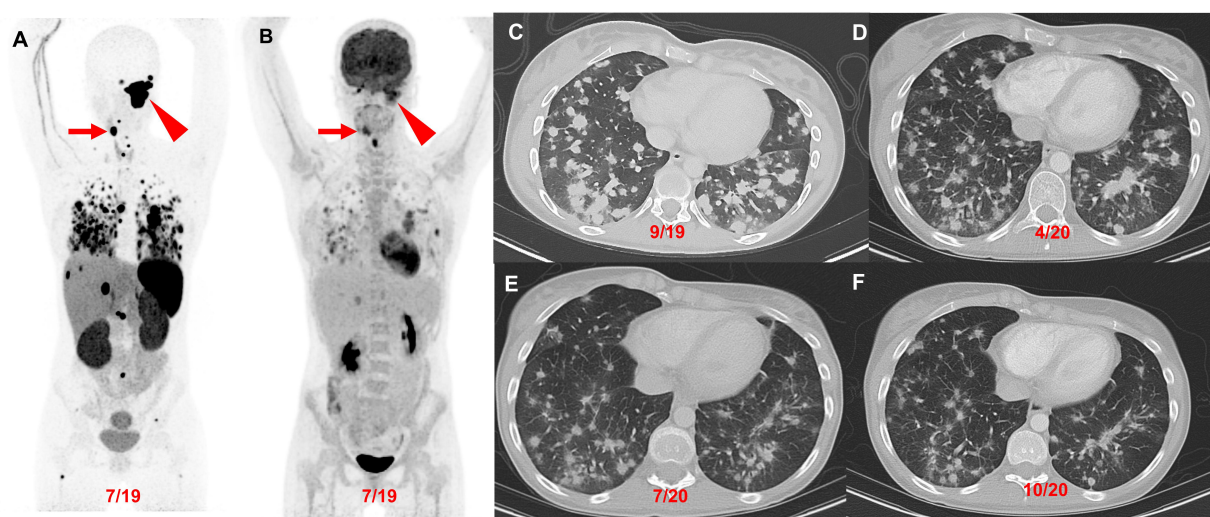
Patient 2 (23-year-old female, *SDHD* pathogenic variant), serial images throughout the course of treatment: Anterior maximum intensity projection images of ^{68}Ga -DOTATATE PET/CT (A) and ^{18}F -FDG PET/CT (B) demonstrate a 7.1 cm complex left jugular mass (red arrowhead) and a 2.5 cm right carotid body paraganglioma (red arrow) with widespread metastatic lesions in the lungs, mediastinum, liver, and bones. The axial contrast CT images (C–F) in the same plane at various time points (09/2019, 04/2020, 07/2020, and 10/2020) show the patient's response (decrease in number of lung lesions and tumor volume) after 4 cycles of CVD therapy (between 10/2019 and 03/2020) with resolution of hypoxemia. CVD: cyclophosphamide, vincristine, and dacarbazine
